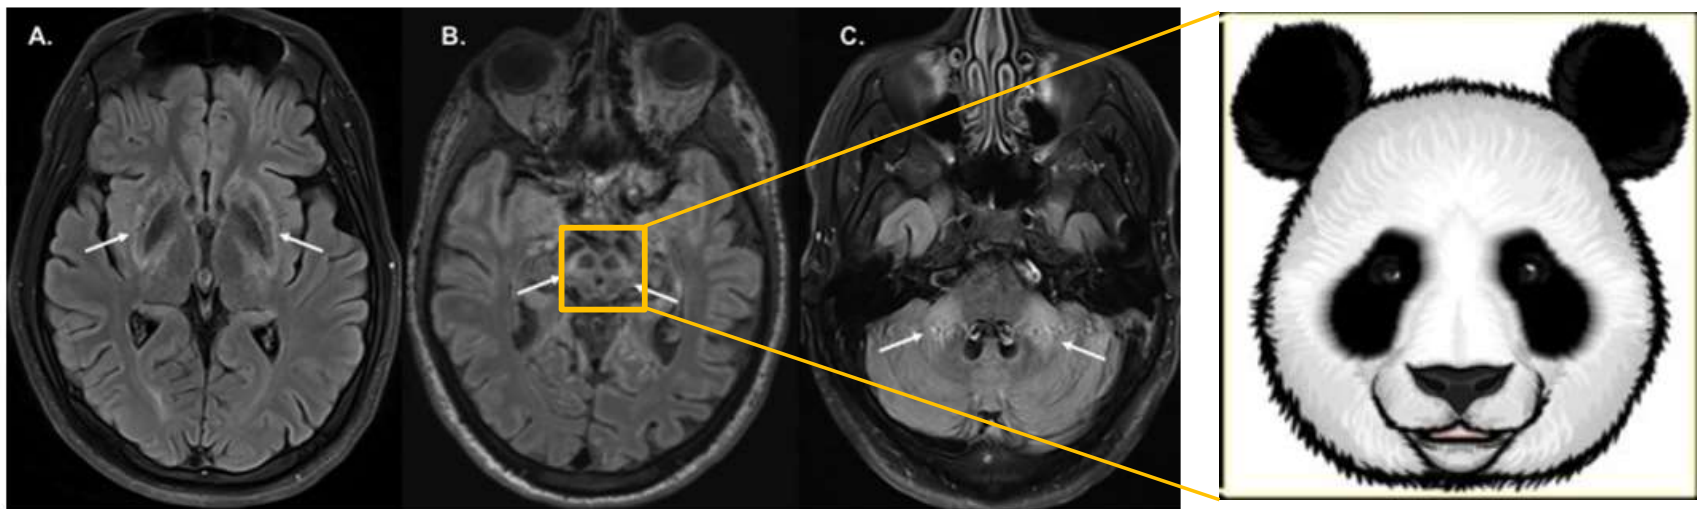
Classical brain MRI findings in Wilson's disease patients. Bilateral high signal intensities on Flair-weighted images in the basal ganglia (A), the mesencephalon (B) (with the sign of the "giant Panda face"), and the cerebellum (C).
